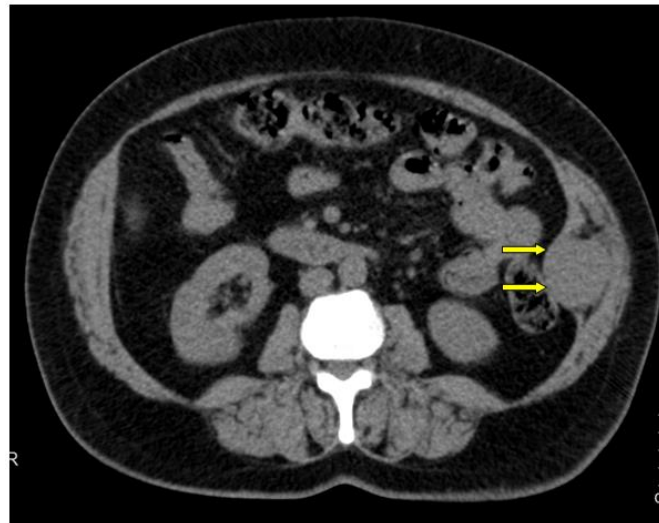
Abdominal CT scan without PDC injection: Axial section: objective a voluminous deep parietal tissue mass of the left transverse muscle with a well-defined rounded shape, regular contours, spontaneously isodense to the neighboring muscles (arrow)
